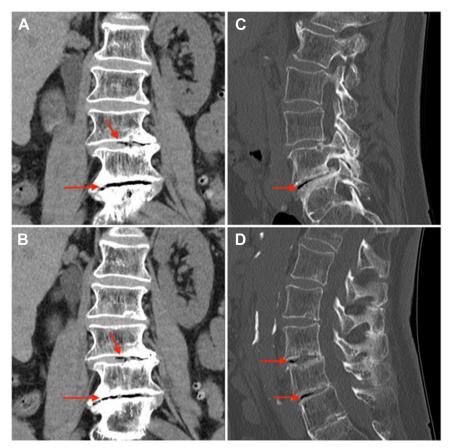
Four images from a CT scan of the lumbar spine. (A, B) Two consecutive coronal images (soft tissue window, slice thickness 3 mm, 173 mA, 120 kv). (C, D) Two consecutive sagittal images (bone window, slice thickness 3 mm, 173 mA, 120 kv). The *red arrows* show the hypodense structures (gas accumulations) in the intervertebral spaces L3/L4 and L4/L5.
